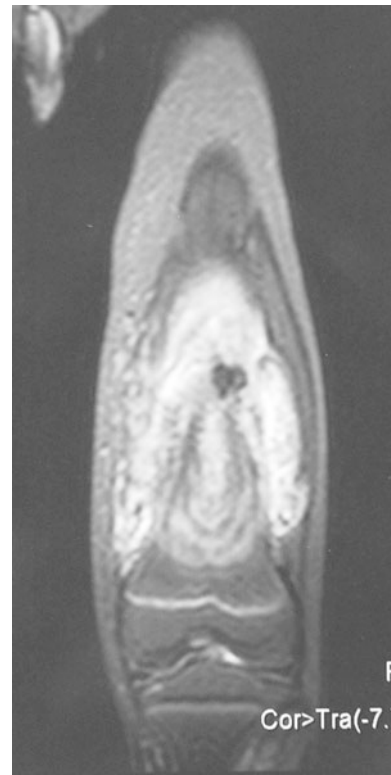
Preoperative coronal magnetic resonance image of the patient. Note that there is no epiphyseal involvement and there is an intact bone bridge in between
